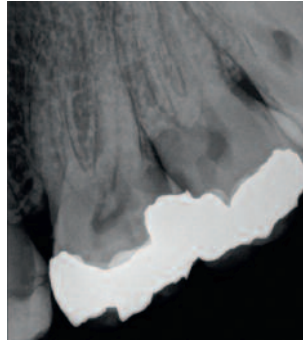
Preoperative radiograph showing deep recurrent caries in teeth # 26 and 27 in close proximity to the pulp
